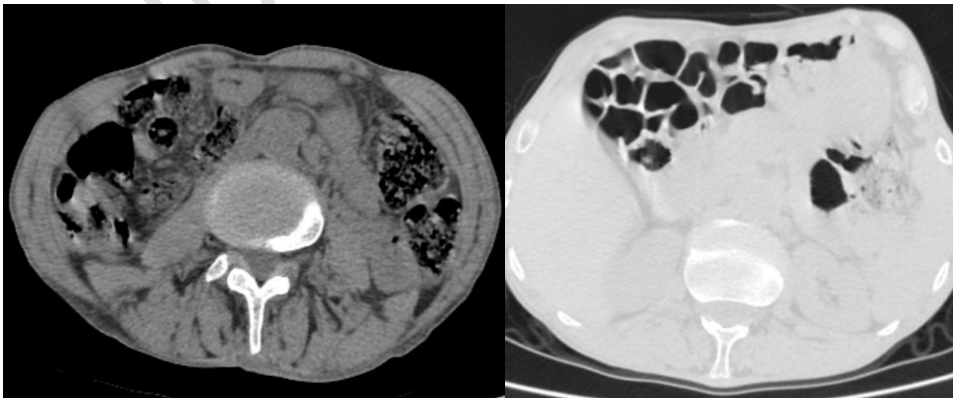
CT scan after 4 months
